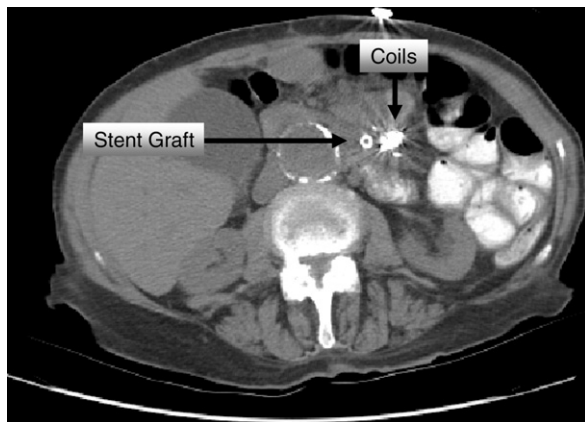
An abdominal computed tomography scan at 1 month after the interventions shows a patent superior mesenteric artery and excluded pseudoaneurysm (arrows).
